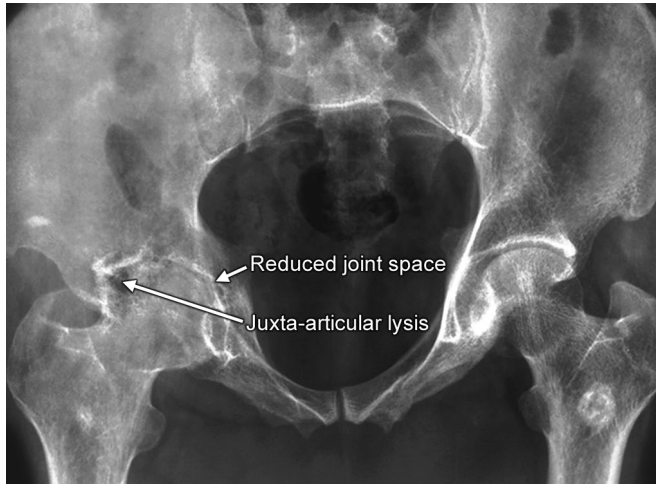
X-ray pelvis with both hips AP view of patient with TB right hip.
